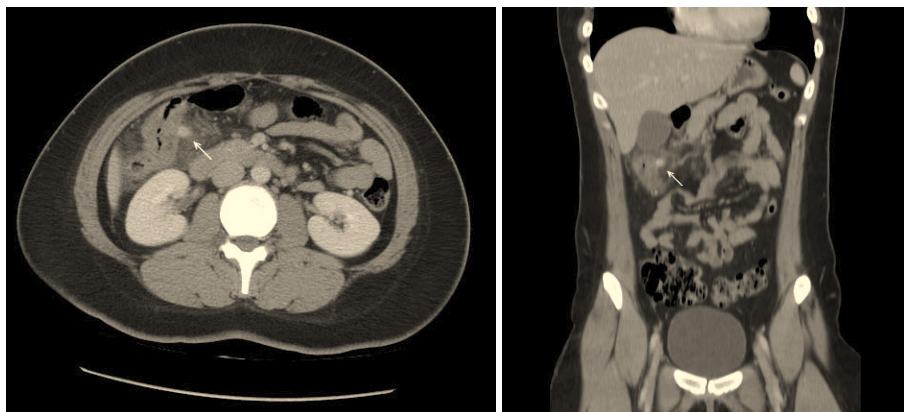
Upper image: Colon diverticulitis (wall thickening and fat bending) on a horizontal CT image (arrow). Bottom image: Coronal cross-sectional CT image of the same patient. (15)
